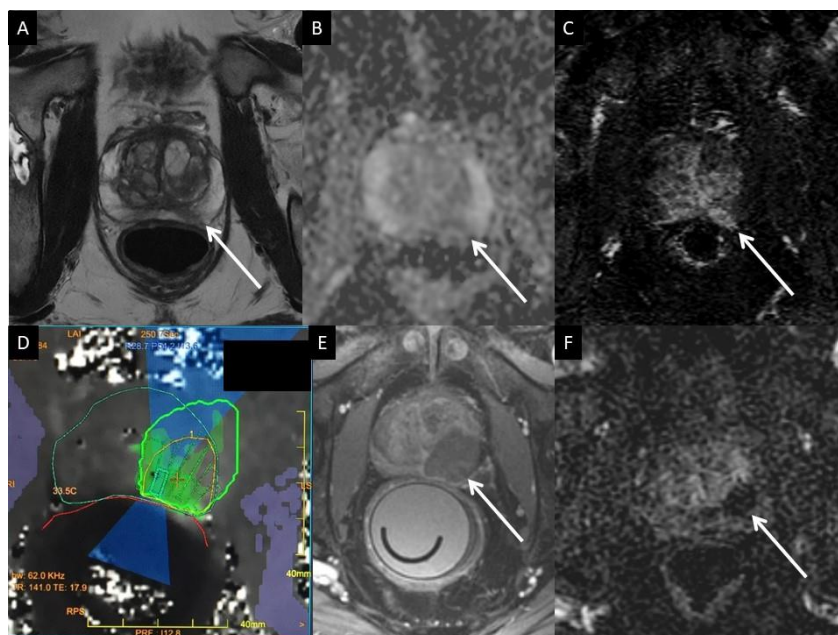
(InSightec): 65-year-old male presents with Gleason 3+4 prostatic adenocarcinoma of the left peripheral prostate. Multiparametric MRI at 3 Tesla demonstrated an area of decreased signal intensity in the left lateral peripheral zone at the prostatic midgland (Panel A, arrow) with corresponding hypointensity on ADC map (Panel B, arrow), and early subtle hyperenhancement (Panel C, arrow). InSightec ultrasound transducer was placed in the rectum and treatment plan created (Panel D). Post-ablation dynamic gadolinium enhanced series demonstrates the corresponding ablation zone to encompass the previously demonstrated cancerous lesion (axial Panel E, arrow and sagittal, Panel F).
